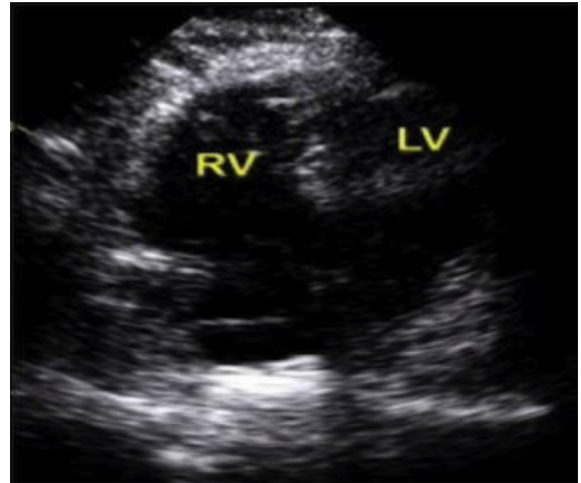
Apical four chamber view of 2D Echo revealing bowing of the inter-ventricular septum and right-sided enlargement (RV/LV > 1) suggestive of massive pulmonary embolism.
